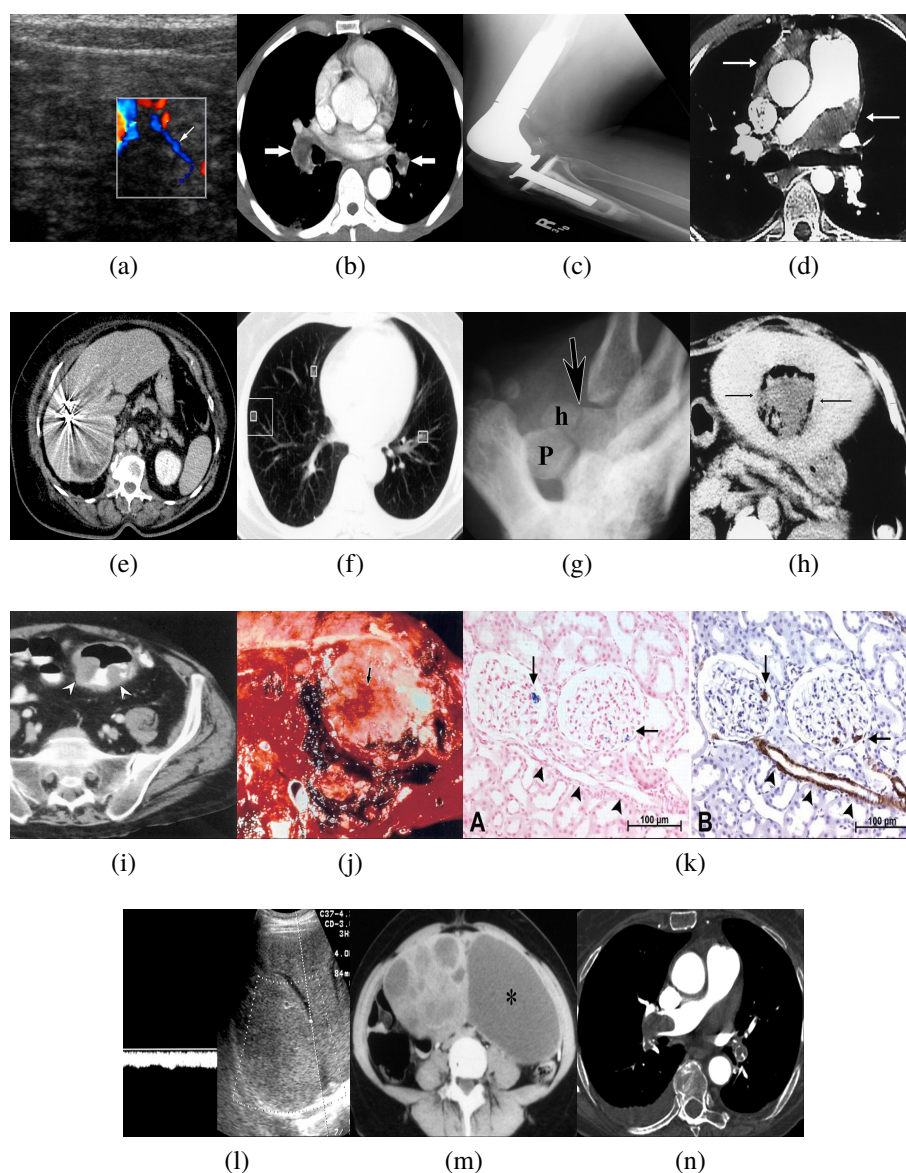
Image examples (positive id) from each of the category numbers listed in Table 1. (a) Doppler ultrasound image (reproduced with permission [52]). (b) CT image with emphysema (reproduced with permission [53]). (c) Knee x- ray image (reproduced with permission [54]). (d) Mediastinal CT image (reproduced with permission [55]). (e) Abdominal CT image showing liver blood vessels (reproduced with permission [56]). (f) Chest CT image showing micro nodules (reproduced with permission [57]). (g) X-ray image containing one or more fractures (reproduced with permission [58]). (h) CT liver abscess (reproduced with permission [59]). (i) MRI or CT of colonoscopy (reproduced with permission [60]). (j) Photograph of tumor (reproduced with permission [61]). (k) Image of muscle cells (reproduced with permission [62]). (l) Image containing a Budd-Chiari malformation (reproduced with permission [63]). (m) Gastrointestinal neoplasm (reproduced with permission [64]). (n) Pulmonary embolism all modalities (reproduced with permission [65]).
